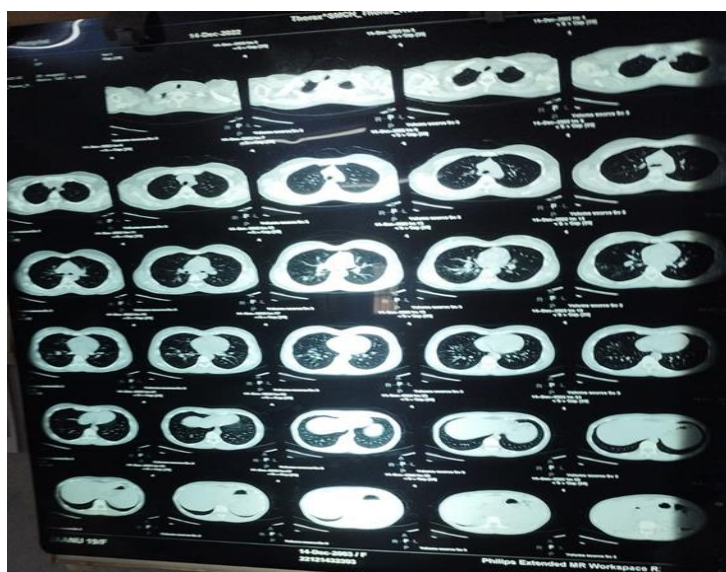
CT scan of the thorax revealing centrilobular nodules with a linear branching pattern in the right lower lobe.
